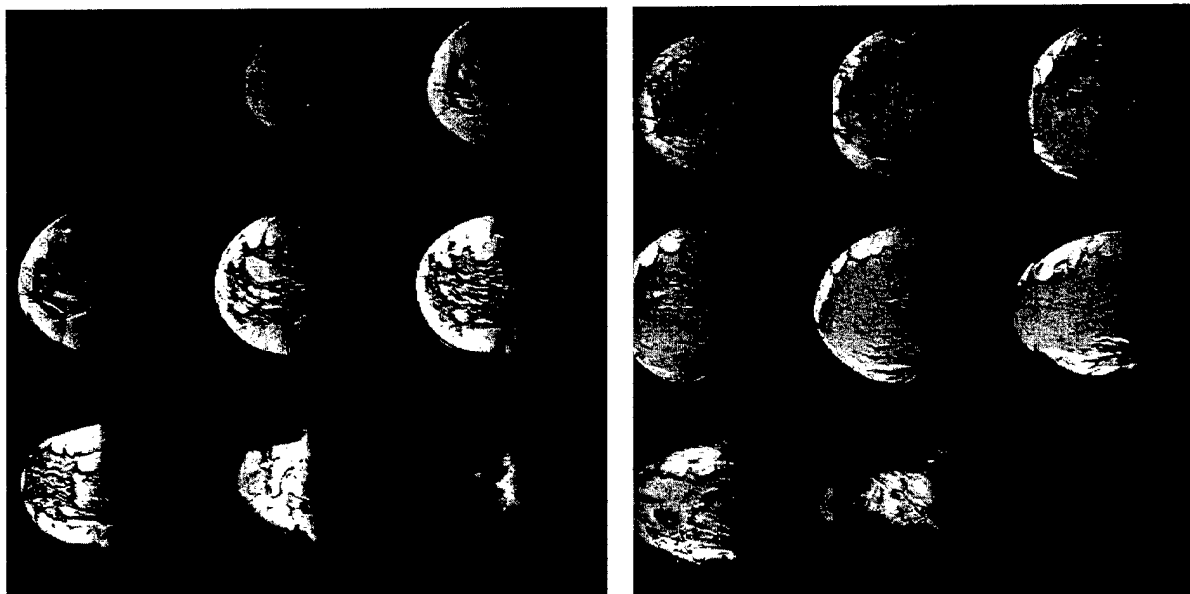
Sagittal, 4T breast images taken by Warren and coworkers as part of sequence optimization for iZQC imaging. These images are conventional MR images, showing the issues with fat-tissue variation and susceptibility changes to be addressed in iZQC imaging.
